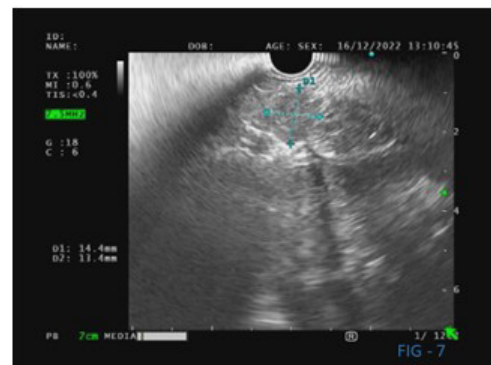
Endoscopic ultrasound revealing a well-defined hypoechoic space-occupying lesion near the pancreatico-duodenal groove.
